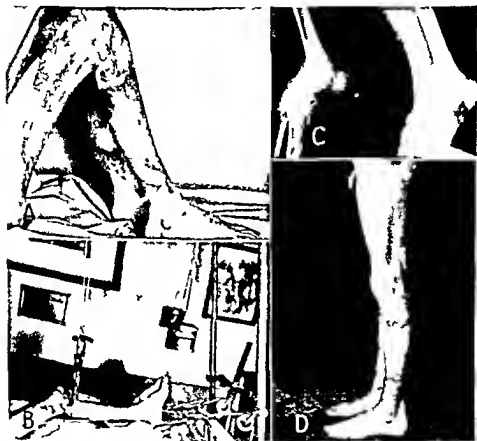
A Extensive turn of both legs, contracture of both knee joints. B The raw surface covered with skin grafts the contracture partially reduced. Posterior subluxation of the tibia due to contracture of posterior ligaments and capsules to be overcome by longitudinal and vertical traction. C X-ray picture of same patient showing on the left the posterior subluxation of the tibia on the right the reduction of the subluxation by traction. Later a plaster cast was applied in this position with incorporation of the wires. D One year after operation.
